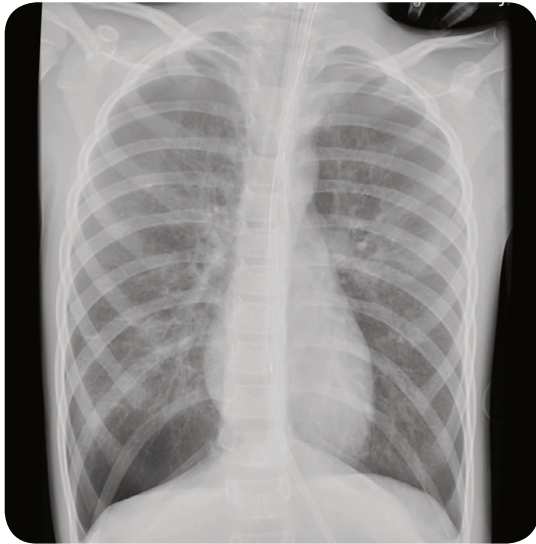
A chest radiograph demonstrating hyperinflation in an individual with chronic asthma. There is a pneumothorax in the right lower zone.
